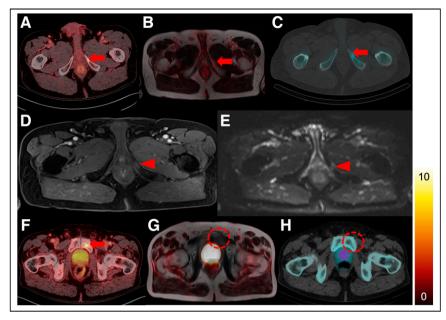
Exemplary cases of UBU regarded as true-positive and false-positive. Axial slices of a patient with suspected UBU on ¹⁸F-PSMA-1007 PET (A, arrow). Suggestive uptake was seen on ⁶⁸Ga-PSMA-11 PET/MRI (B, arrow) and on bone scan SPECT/CT (C, arrow). Corroborating these findings, the MRI showed contrast enhancement (D, arrowhead) and diffusion restriction (E, arrowhead). Therefore, the bone uptake was rated as true-positive. A second patient is shown in F–H. Axial slices of a patient with unspecific ¹⁸F-PSMA-1007 uptake rated as false-positive in left inferior pubic ramus (SUV_{max}, 5.6) without any CT correlate (F, arrow) are shown. There was no suspicious finding either in ⁶⁸Ga-PSMA-11 PET/MRI (G, dashed circle) or bone SPECT/CT (H, dashed circle). Therefore, this bone uptake was considered as false-positive.
